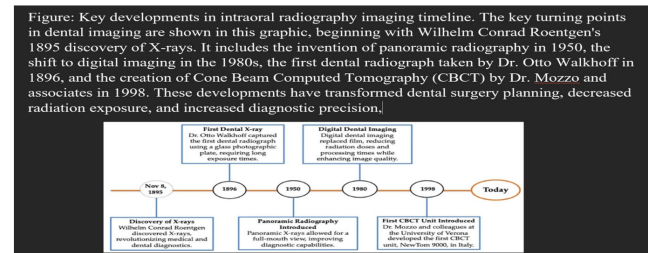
History of CBCT [23]
